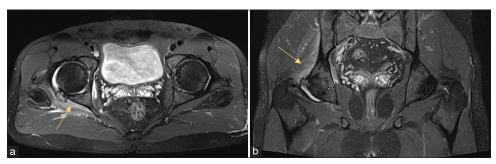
Proton density fat-saturated axial (a) and coronal (b) magnetic resonance imaging images show increased signal intensity in the surrounding soft tissues (arrows), suggesting acute inflammatory changes.
